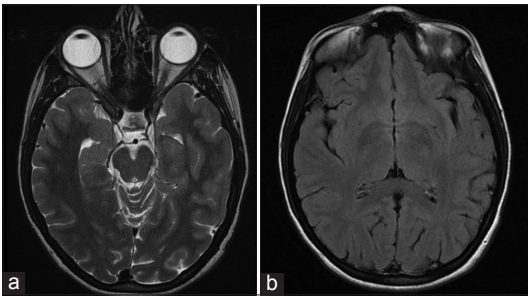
Brain magnetic resonance imaging (MRI) T2 (a) and MRI fluid attenuation inversion recovery (b) findings in levamisole-induced vasculitis.
